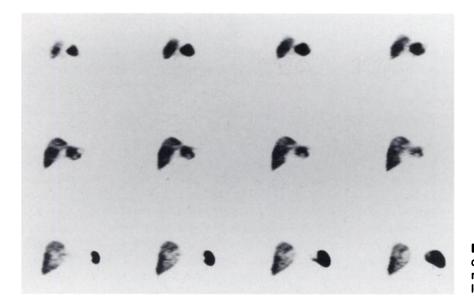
SPECT scan confirms a focal area of increased activity in the anterior aspect of the lateral segment of the left lobe of the liver.
